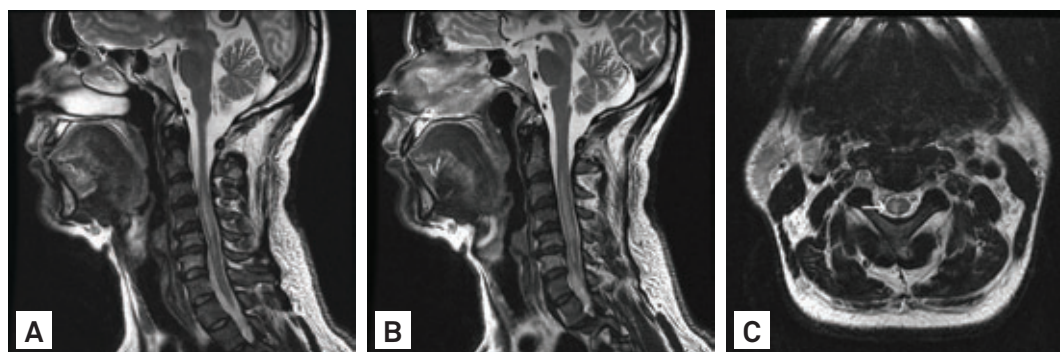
Sagittal T2-weighted MRI with hypersignal in spinal cord at levels C2-C6, without expansion effect (A and B). Axial T2-weighted MRI with hypersignal in right hemi-spinal cord (C).
